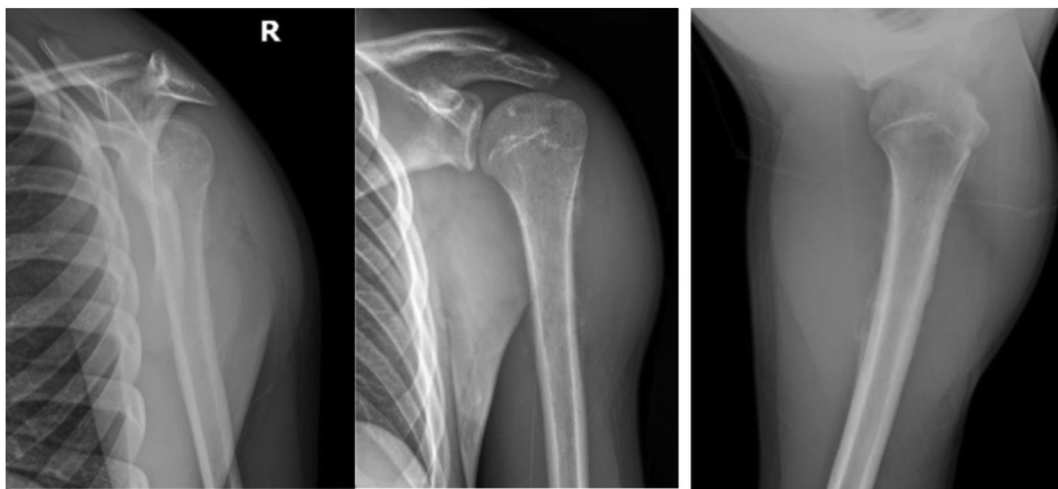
Initial three-view radiographs.
